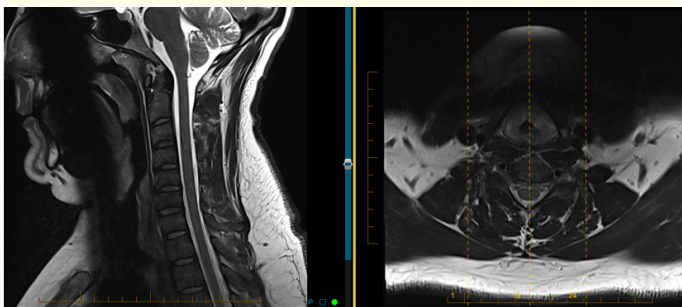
MRI Cervical Spine (6/3/18) Pre - op.
